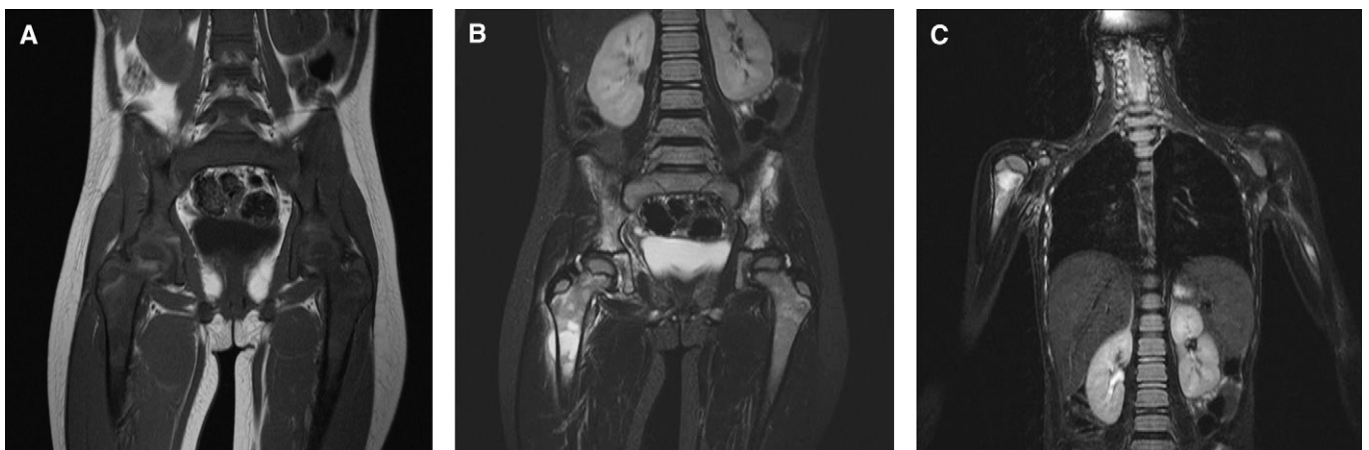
Magnetic resonance images as follows: (A) coronal T_1 -weighted image (TE = 14 ms, TR = 429 ms) of the pelvis and proximal femora, (B) coronal short tau inversion recovery (STIR) image (TE = 74 ms, TR = 4500 ms) of the pelvis and proximal femora, and (C) coronal STIR image (TE = 74 ms, TR = 5620 ms) of the thorax.
